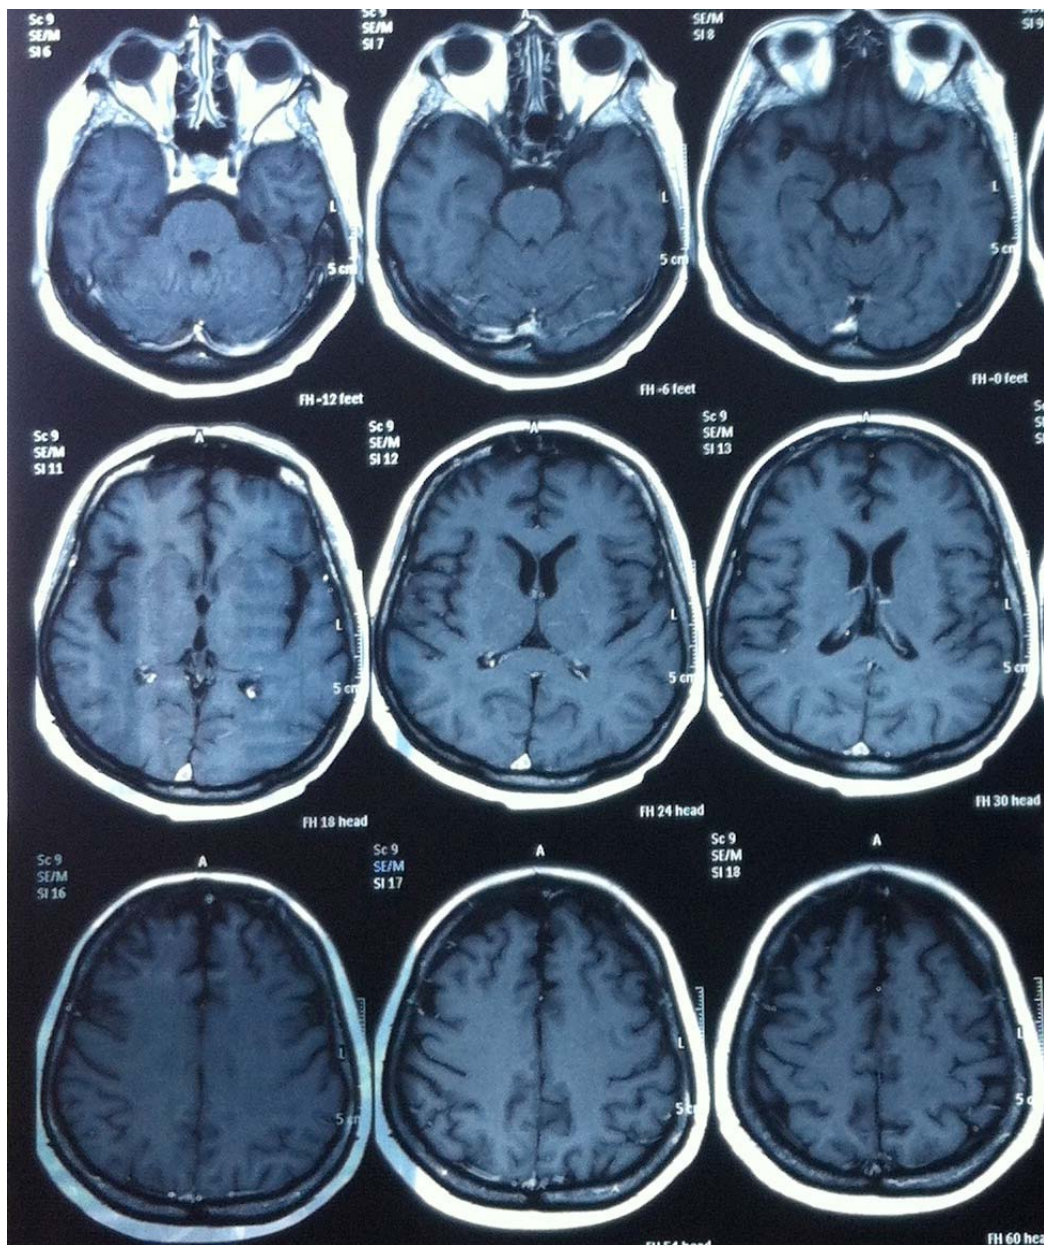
Patient's brain Magnetic Resonance Imaging, without pathological alterations.
